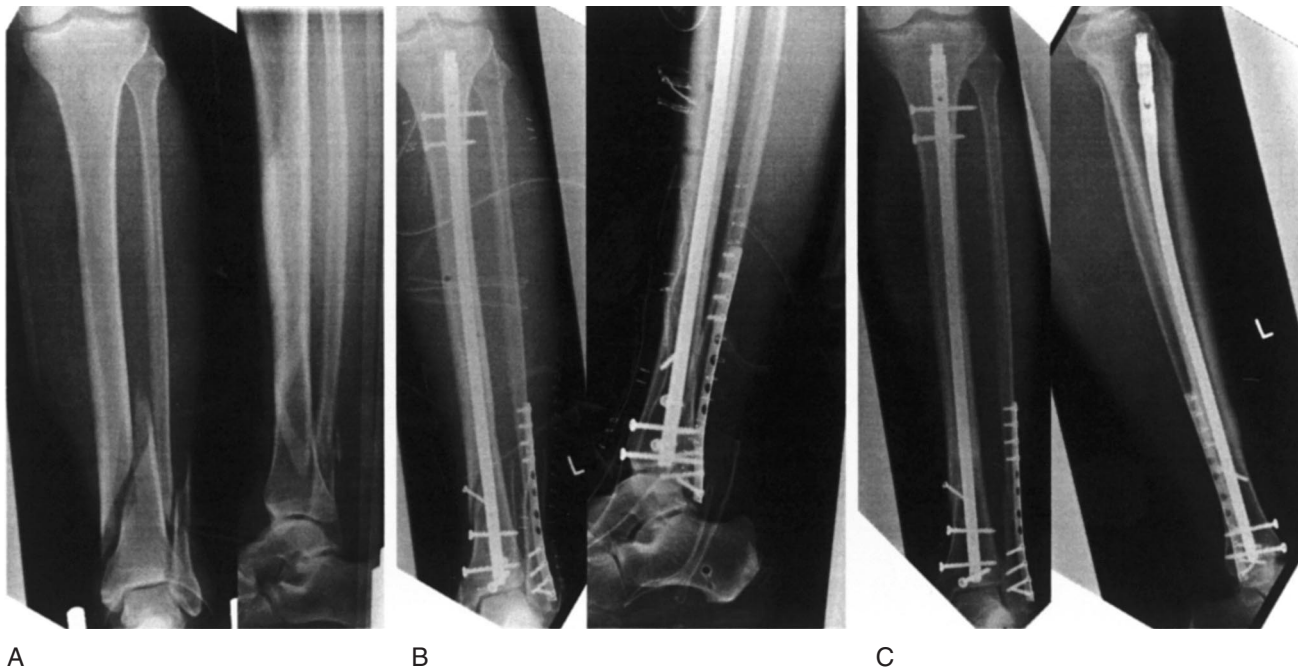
A: A 66-year old male sustained an II° open complete lower leg fracture in a motorcycle accident. B: Three days after primary stabilization with a bridging external fixator, intramedullary nailing with an additional lag screw fixation was carried out. To ensure secure fixation 4 distal locking bolts were used. C: Radiographs at one year show the healed tibial fracture in anatomical alignment.
